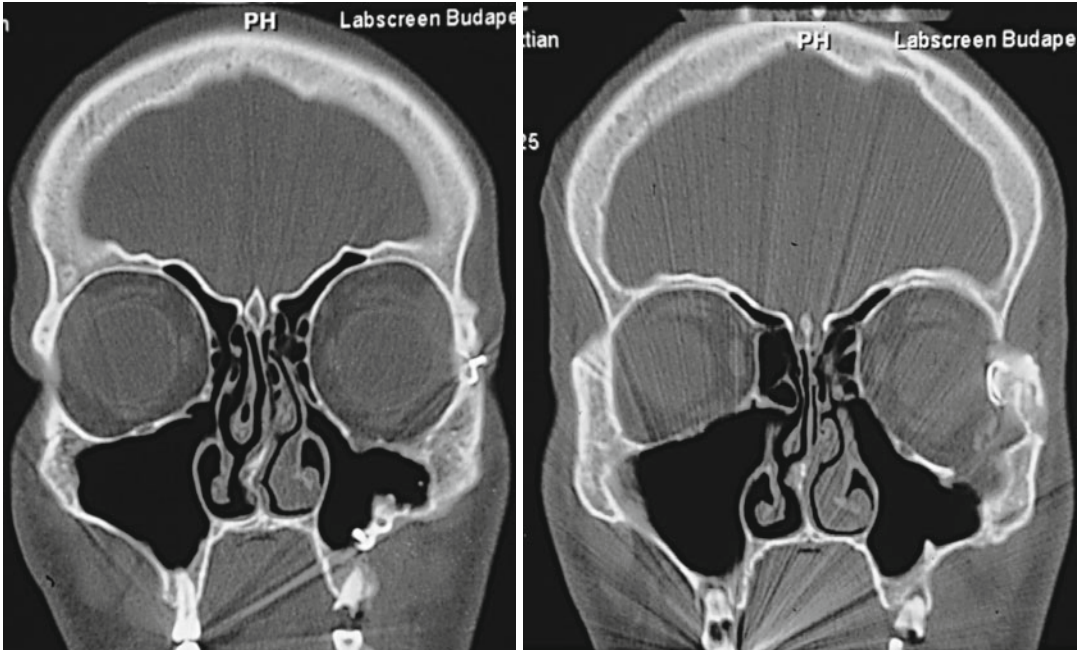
Coronal CT: severe orbital floor defect and zygomatic bone dislocation
